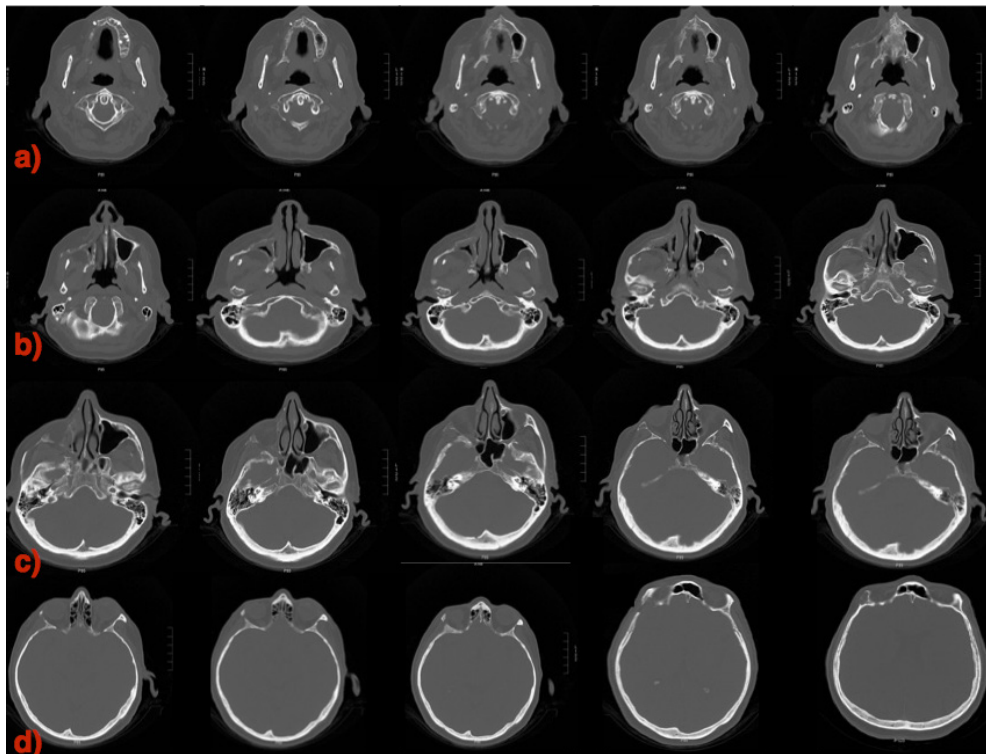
CT after 6 months. a) Reparative sclerosis in the alveolar bone and palate. b) Bone repair with sclerosis of the zygomatic bone and collapse of the right maxillary sinus. c) Bone repair with sclerosis of the lateral wall of the right orbital bone. d) Bone repair with sclerosis of structures initially involved in lytic alteration.
